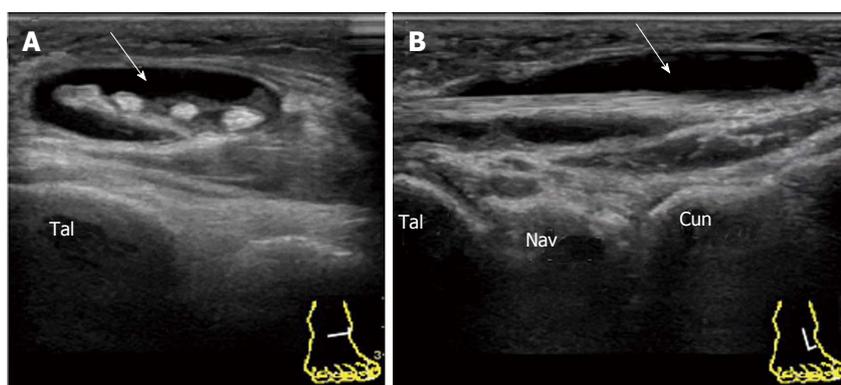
Serous tenosynovitis of the extensor digitorum longus in rheumatoid arthritis. Transverse (A) and longitudinal (B) grey-scale sonogram of the dorsal aspect of the EDL shows marked expansion of the tendon sheath with anechoic synovial effusion (arrow). Tal: Talus; Nav: Navicular; Cun: Cuneiform; EDL: Extensor digitorum longus.
